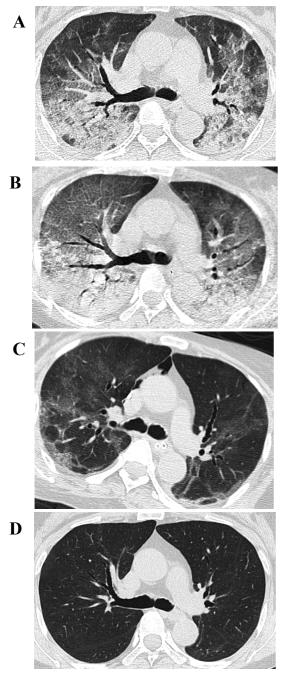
Serial changes in chest high-resolution computed tomography (HRCT) findings.
